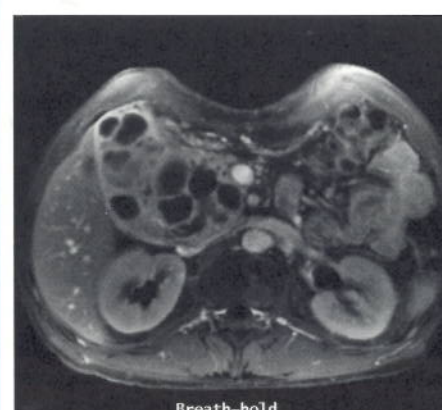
Water excitation FLASH technique for breathhold FatSat T1-weighted abdomens.
